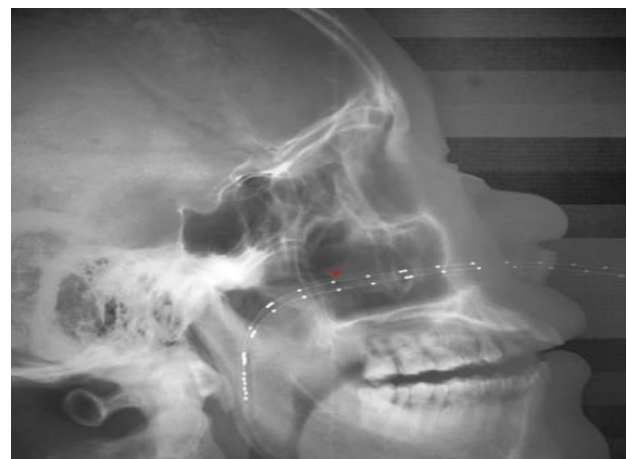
Orthogonal X-ray of the patient in supine position with dummy source position (Lateral view).¹³
